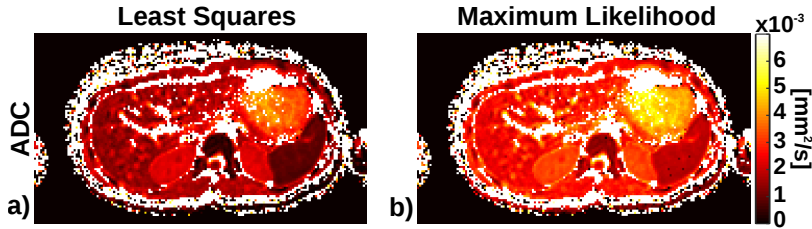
ADC estimated maps of a liver DWI acquisition estimated with a least squares estimator and a maximum likelihood estimator, a) and b), respectively, for a particular set of b-values. Note the differences on the estimated maps for both estimators.
